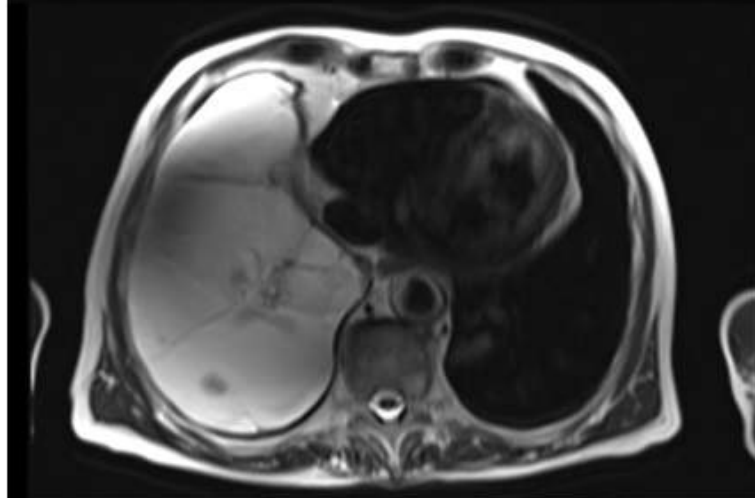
T1-weighted axial (Panel A) and coronal (Panel B) fat-saturated VIBE images of a patient with pleural effusion, taken post-contrast using a 3T Siemens Magnetom PRISMA[®] MR scanner at the Glasgow Clinical Research Imaging Facility, QEUH
